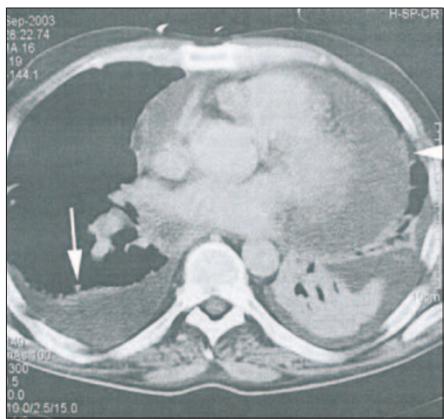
CT scan thorax shows bilateral pleural effusions and a large pericardial effusion
